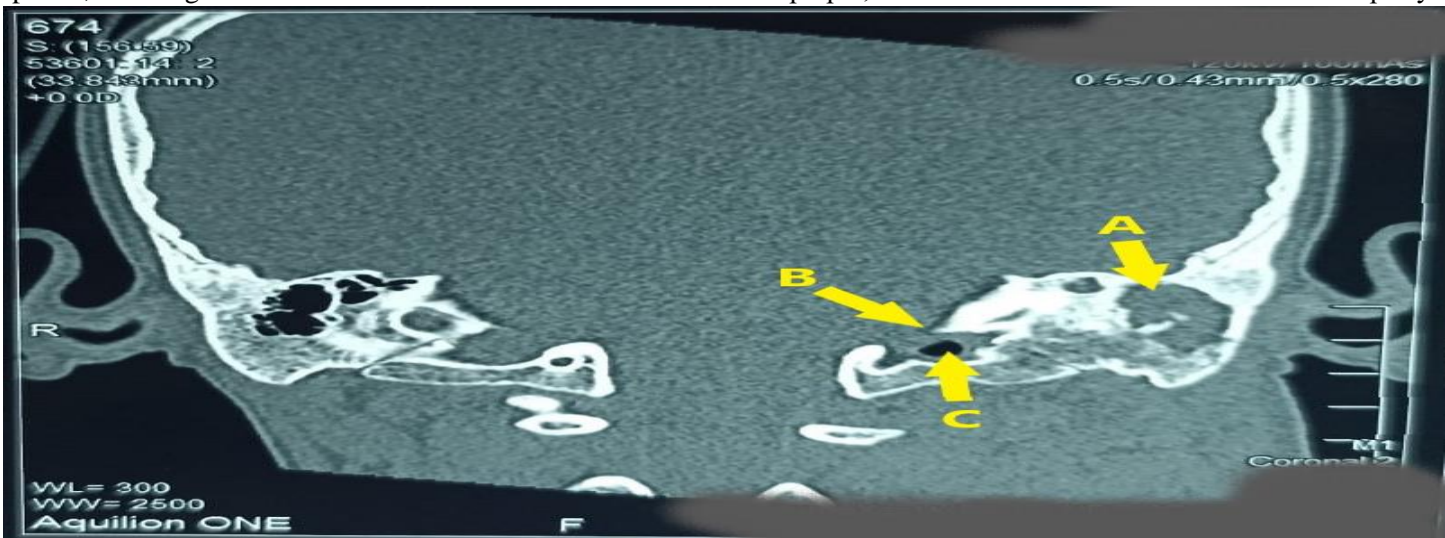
Gradenigo Syndrome: CT scan showing the attenuation of left middle ear cavity, left mastoid air sinus (A), and left petrous apex (B) with the osseous disruption and bone resorption, resulting in the focal meningeal inflammation (C). The clinical examination confirms involvement of the facial nerve and abducent nerve.
